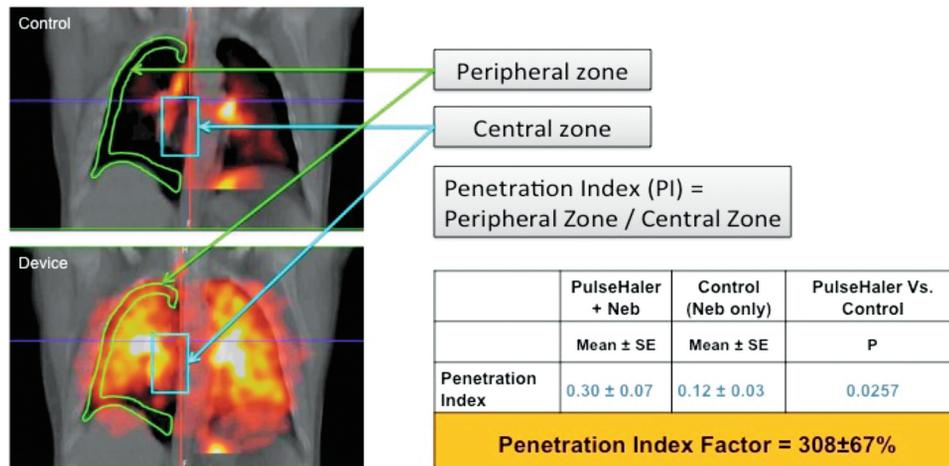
Representative scintigraphic images and visual depiction of how penetration index is calculated. The table contains a summary of the results (table headings are described in the text).
